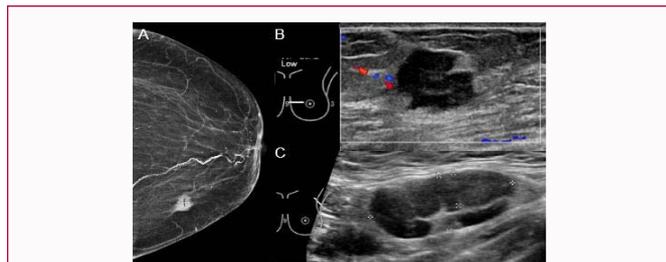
A) The bilateral mammography showed an irregular dense mass lesion seen in the left breast lower inner quadrant measuring 1.7 cm x 1.5 cm. No suspicious micro calcifications or parenchymal distortion. B) The ultrasound of the left breast showed an irregular partially defined hypoechoic mass seen in the left breast at 9 o'clock position with no architectural distortion or posterior acoustic shadowing measuring around 1.4 cm x 1 cm, corresponding to the mammographic findings. C) The ultrasound showed also an enlarged and distorted lymph nodes seen in the left axilla.
